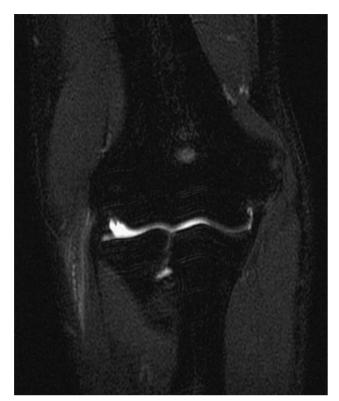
Coronal T2-weighted image from MR arthrogram showing a ulnar collateral ligament tear in a young baseball pitcher. Note the disrupted orientation of the proximal fibers.
